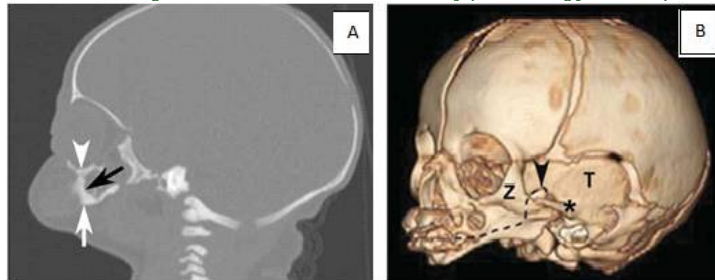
Postnatal CT of the affected neonate. A, Postnatal off midline sagittal head CT showing fusion (black arrow) of the mandible (white arrow) and maxilla (arrowhead). Fusion was seen on multiple slices, more easily visualized on the 3D CT reconstruction (B). B, Postnatal 3D CT reconstruction of facial bones. Sagittal view depicts fusion of the maxilla and the mandible. The fusion in this case involved bilateral bony fusion of the mandibular and maxillary alveolar processes, with a small anterior slit remaining. The fusion also included fusion of the proximal parts of the mandibles, the ascending rami, to the posterior portions of the maxillas and to the zygomas bilaterally. However, the ascending rami of the mandibles were not fused to the zygomatic processes (asterisk) on either side. The coronoid processes of the mandible (arrowhead) are visualized, pointing to the most proximal aspect of the mandible. T indicates temporal bone; and Z, zygomatic bone. The dotted line represents the expected area of separation between the mandible and the maxilla.
